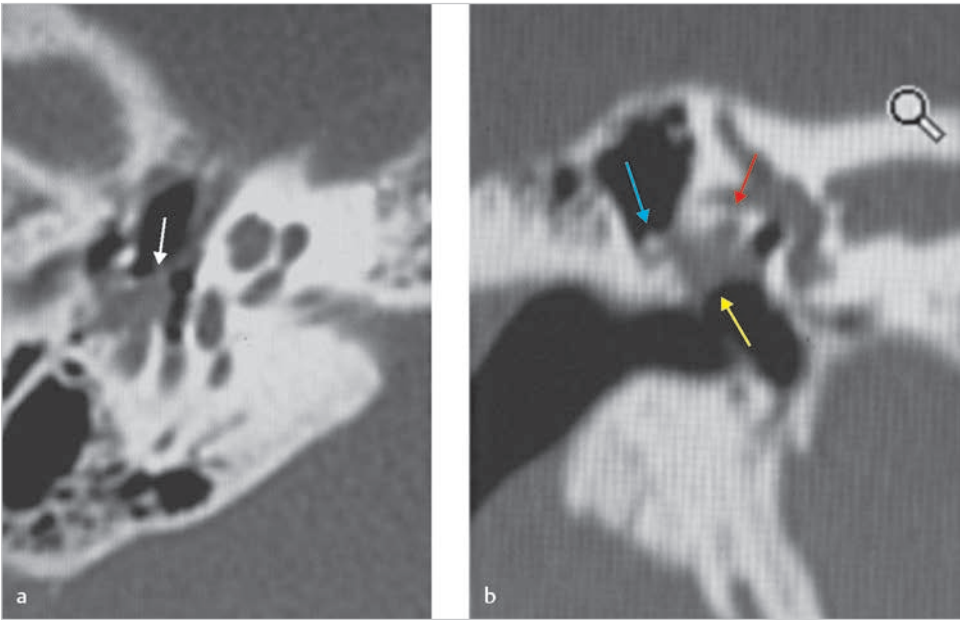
The axial computed tomography (CT) (a) demonstrates limited extension of the cholesteatoma to the posterosuperior part of the tympanic cavity. An erosion of the incudostapedial joint is identified (arrow), The coronal CT (b) demonstrates small extension of the cholesteatoma superiorly to the tympanic segment of the facial nerve (red arrow), but it does not surpass the short process of the incus (blue arrow).
